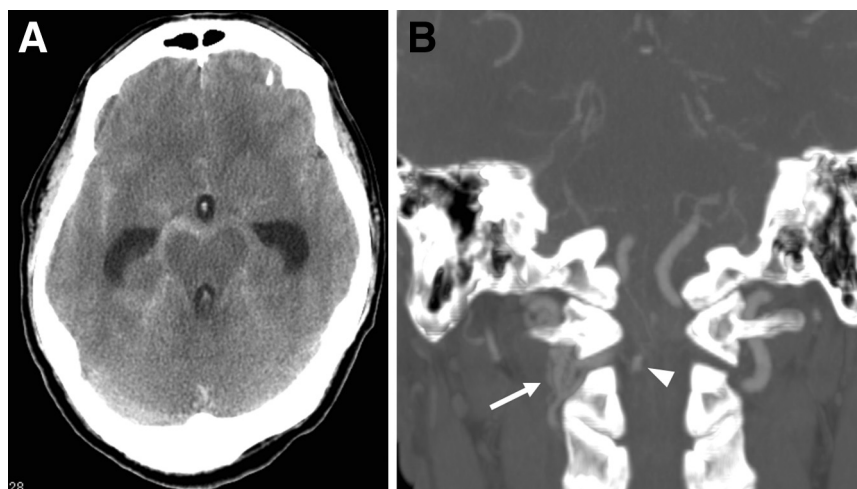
(A) Axial computed tomography (CT) scan of the head showing subarachnoid hemorrhage and intraventricular hemorrhage. (B) Coronal CT scan of the cervical spine with contrast demonstrating anterior spinal artery aneurysm (arrowhead) and dilated epidural veins (arrow).
